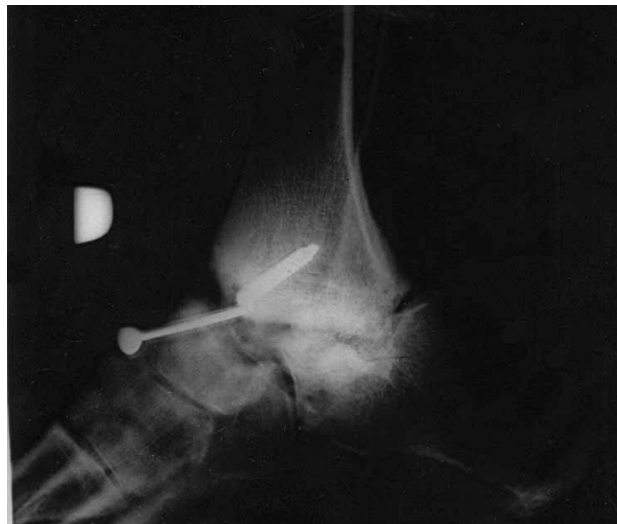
Lateral radiographs of the ankle 26 months after first operation showed failed arthrodesis.
